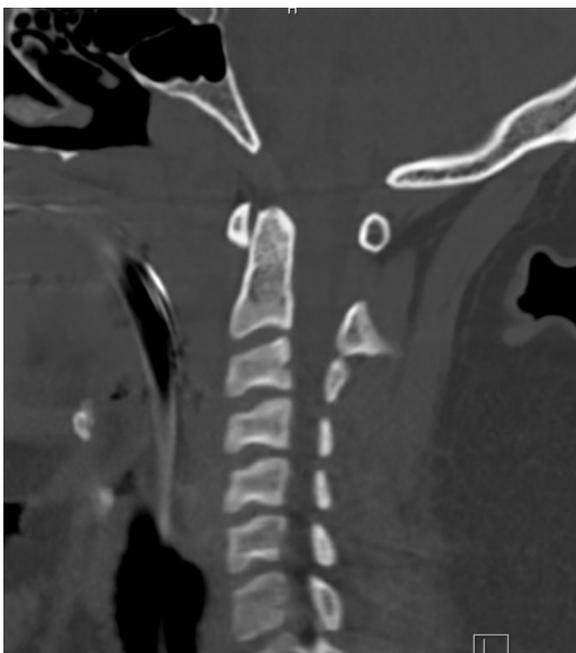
Sagittal image of computed tomography demonstrating atlanto-occipital dissociation.
